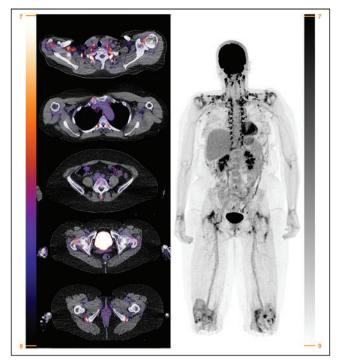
<sup>18</sup>F-FDG PET/CT imaging at time of diagnosis (before treatment) and after 1 y of treatment in 67-y-old male GCA patient. At time of diagnosis, patient presented with complaints of PMR, accompanied by C-reactive protein (CRP) of 121 mg/L and ESR of 106 mm/h. Patient had been treated with prednisolone and subsequently with methotrexate. At 1 y, CRP remained elevated despite methotrexate treatment. Patient did not experience GCA-related symptoms at that time but had some symptoms of PMR. (Left) Axial <sup>18</sup>F-FDG PET/CT fusion image of head and whole-body maximum-intensity-projection (MIP) image at time of diagnosis. Moderately increased uptake (higher than background) can be seen in maxillary arteries. Significantly increased uptake (higher than liver) can also be found in aorta and carotid, subclavian, axillary, iliac, and femoral arteries (PETVAS = 27). In addition, moderately increased uptake (similar to liver) can be observed surrounding shoulders and hips. (Right) Whole-body MIP image and axial <sup>18</sup>F-FDG PET/CT fusion of head after 1 y of treatment. Slightly increased uptake (similar to liver) can be observed in aorta and carotid, subclavian, axillary, iliac, and femoral arteries (PETVAS = 13). No uptake was found in maxillary arteries. Moderately increased uptake was found surrounding hip joints. ESR = erythrocyte sedimentation rate.
